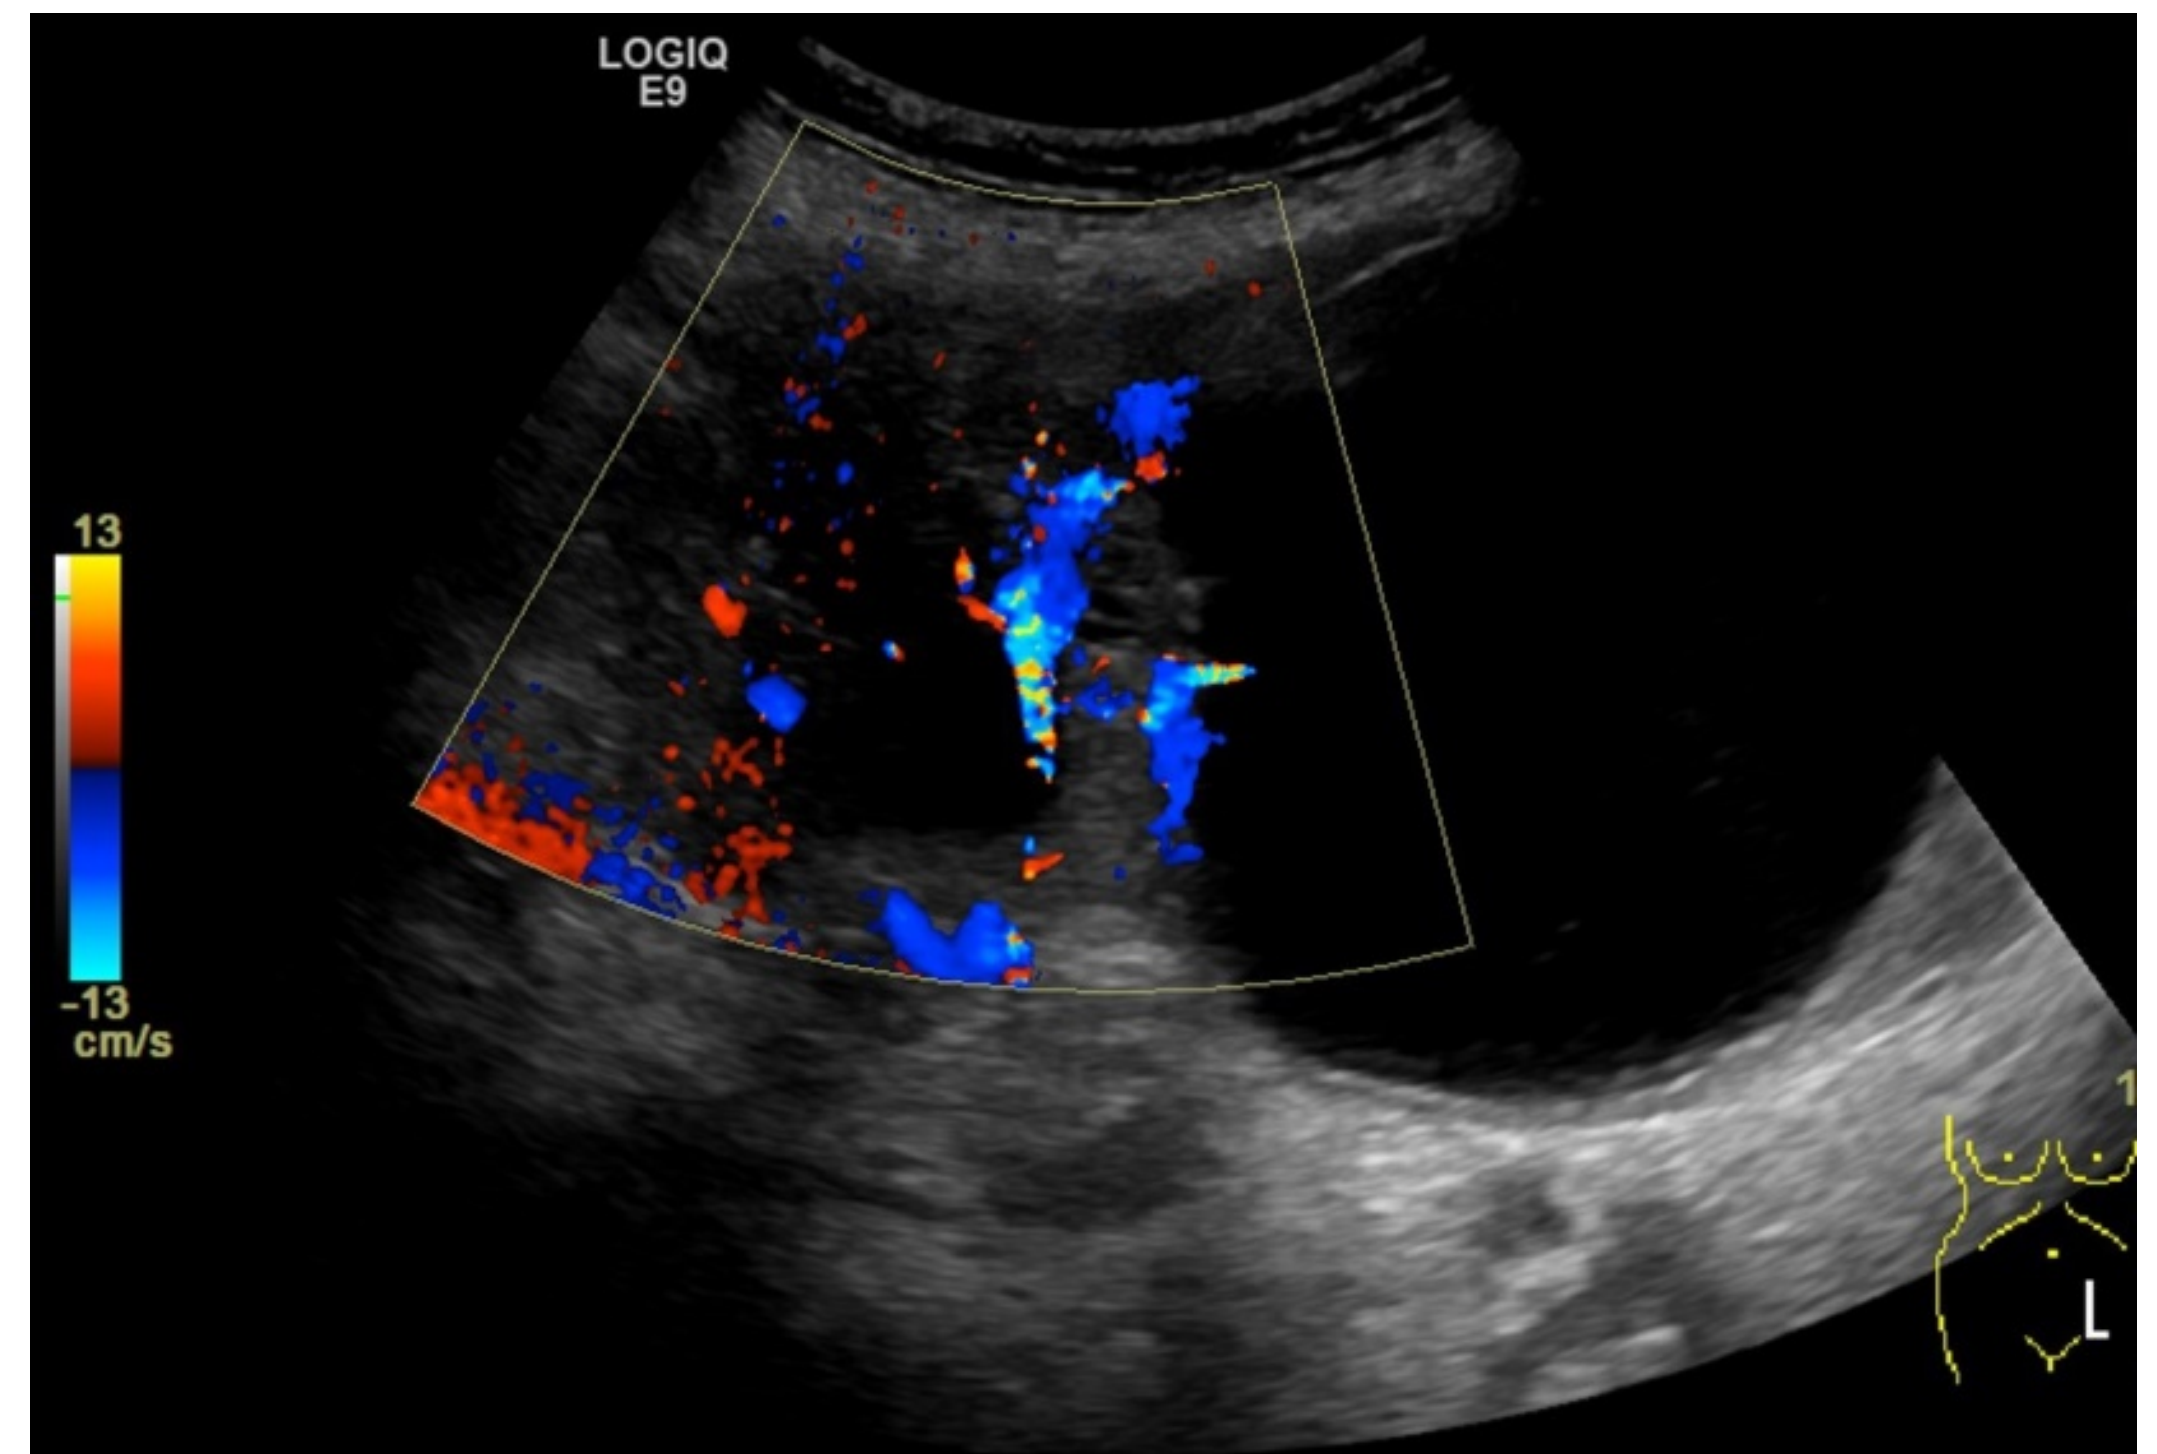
Ultrasound with Doppler demonstrated a large cysts within the left adnexa separated by a hypervascular septum.
